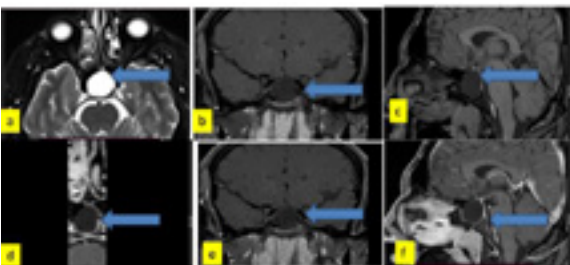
preoperative MRI patient number. a: axial T2, b: coronal T1, c: sagittal T1 non-enhanced MRI, d: T1 axial, e: T1 coronal, f: sagittal T1 contract enhanced MRI of pituitary gland showing widened sella by well defined pituitary mainly cystic macroadenoma
